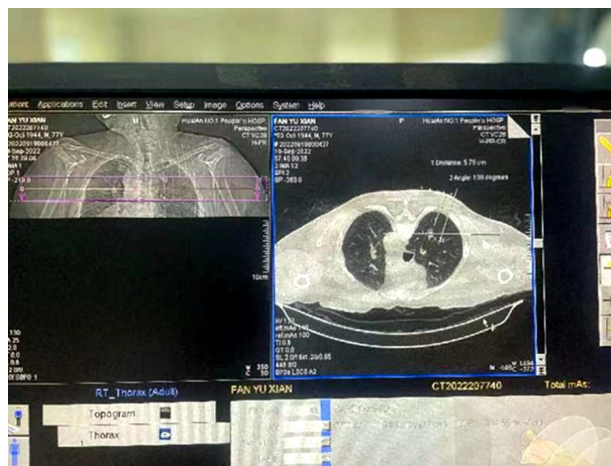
The prototype CT image of pulmonary nodules and lung puncture localization.
